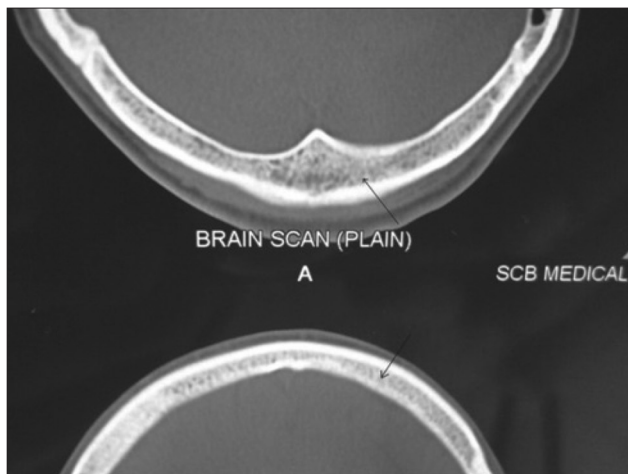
Bone window in CT scan showing increased marrow proliferation with thin cortical bone margins
